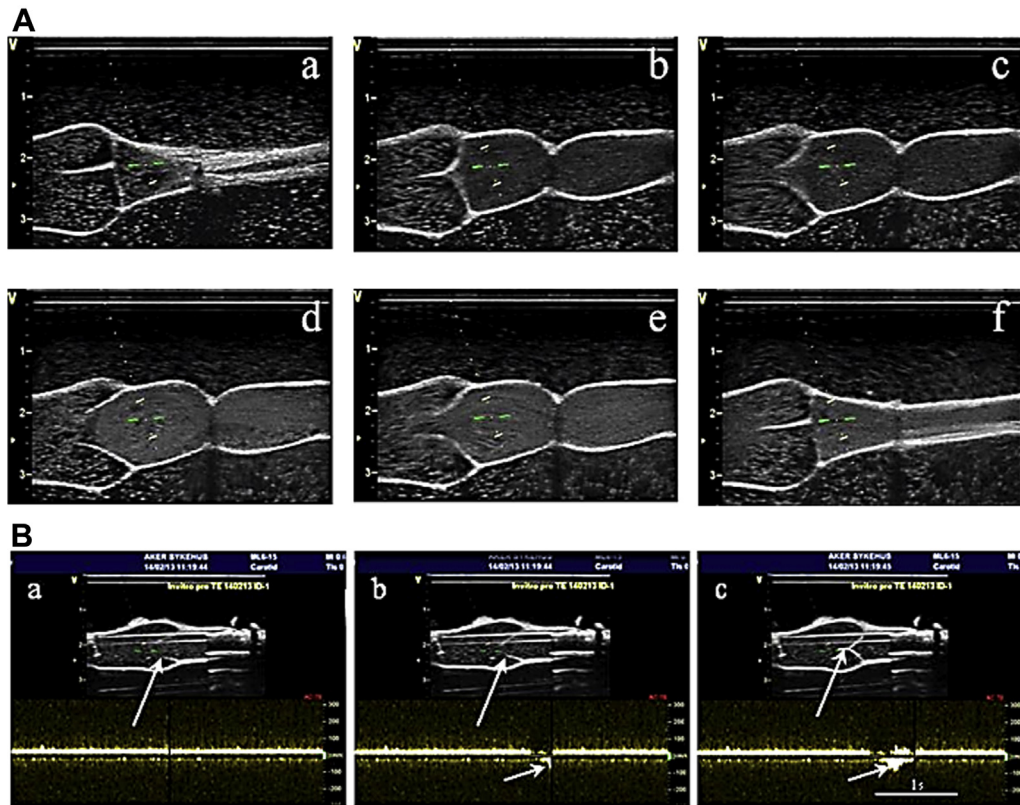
Functional testing of tissue-engineered valve-containing veins. A, Two-dimensional pictures from ultrasound show a longitudinal projection of the vein segment: a closed valve (*a*); the gradual opening of the valve during antegrade flow (*b-d*); and the closing of the valve with retrograde flow (*e* and *f*). B, The yellow Doppler scale gives the valve closure time in seconds.
